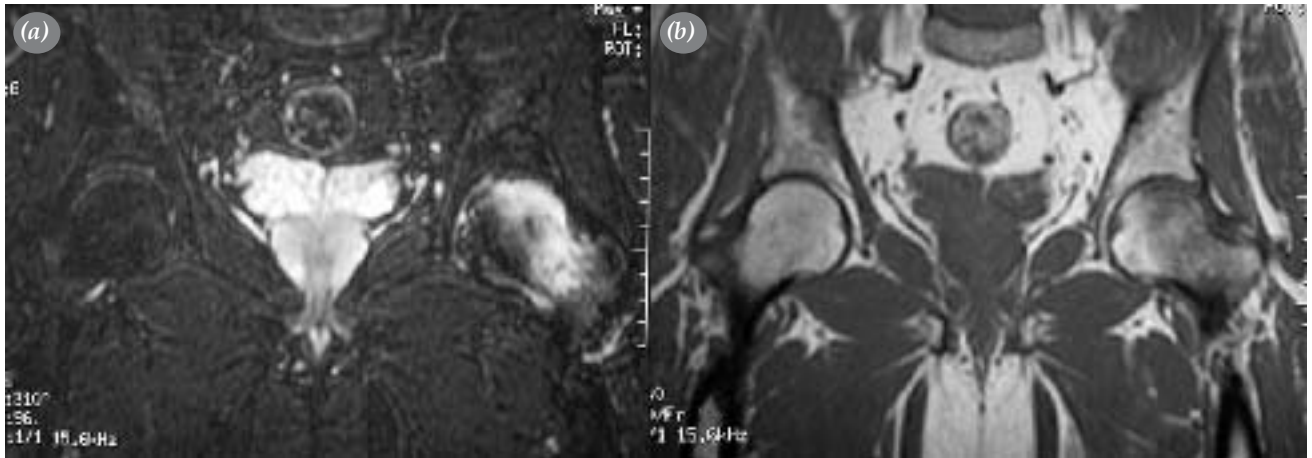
A less than 1 cm intertrochanteric region bone marrow edema is observed in this T₂-weighted fat-suppression coronal hip MRI, (a) of a 50-year old male patient. The T₁-weighted image, (b) of the same patient demonstrates a subchondral fracture line appearing as a hypointense line.
